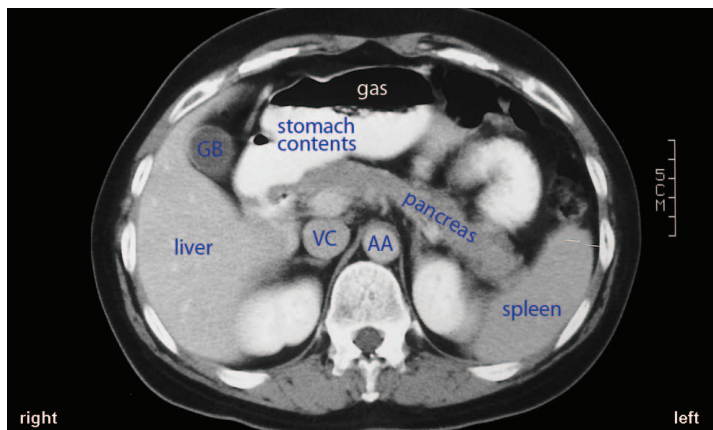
Healthy Patient's CT Scan
